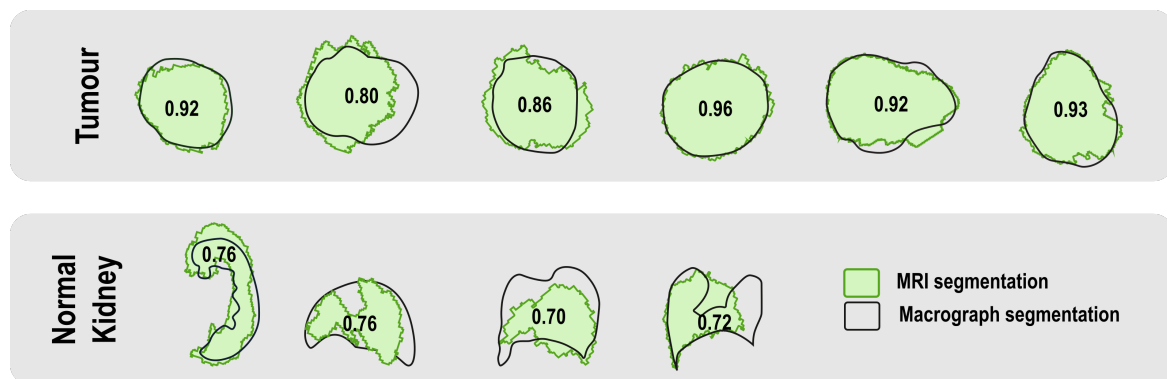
Overlay and Dice similarity coefficients of the segmentation on the T_1w MRI sequence (green) and the macrograph of the tissue slice (black). Adapted from: Crispin-Ortuzar M*, Gehrung M*, Ursprung S*, *et. al.* Three-Dimensional Printed Molds for Image-Guided Surgical Biopsies: An Open Source Computational Platform. JCO Clinical Cancer Informatics. 2020; 4, 736-748.
